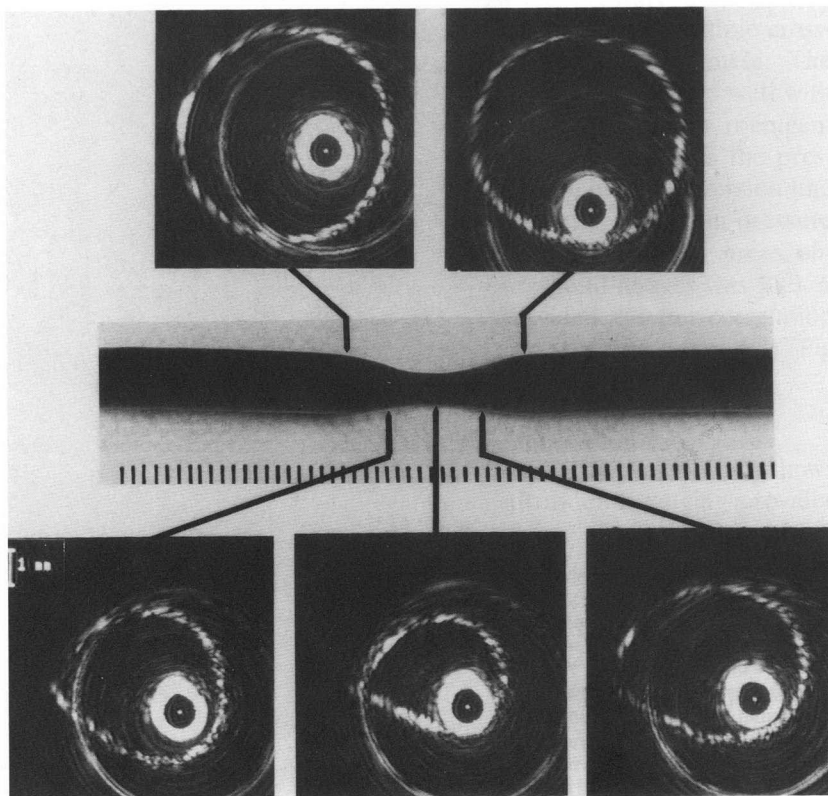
Ultrasound images from a plastic tube stenosis obtained at 4 mm intervals. Ultrasound images delineated the changes in morphology and the degree of the artificial stenosis created in the plastic tube model. The first central echo reflection is caused by the introducing sheath of the ultrasound catheter. There is also a secondary circular echo reflection from the sheath that has smoother echoes than those from the plastic tube.
